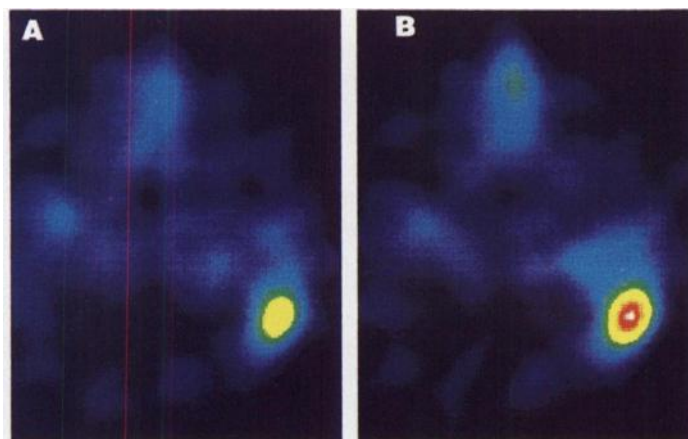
Antigranulocyte antibody scintigraphy. Transversal SPECT scans 24 hr postinjection. Corresponding slices to Figure 1. Note the intense tracer accumulation in the superficial metastasis whereas the activity at the location of the second metastasis, which is located more anterior and medial towards the center of the head, does not exceed the activity of the contralateral region.
